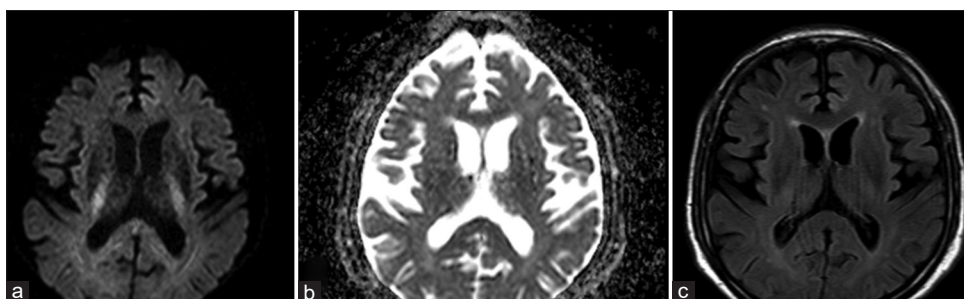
Diffusion-weighted image, apparent diffusion coefficient, and T2/fluid-attenuated inversion recovery imaging showing normal magnetic resonance imaging
